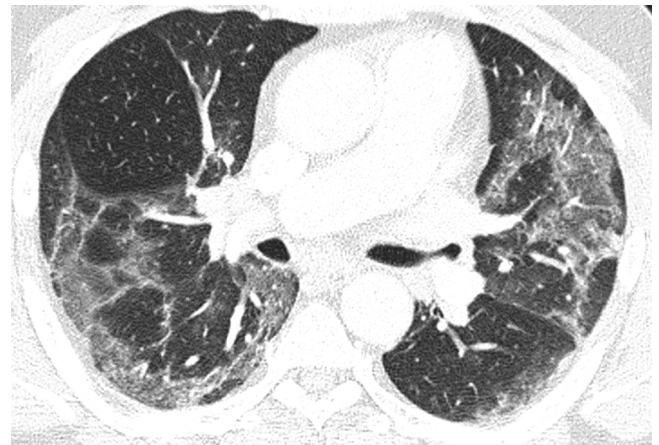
Moderate extent of opacifications. Axial reconstruction of a CT in lung window showing moderate affection with ground glass opacities in the upper and lower lobes of both lungs.
